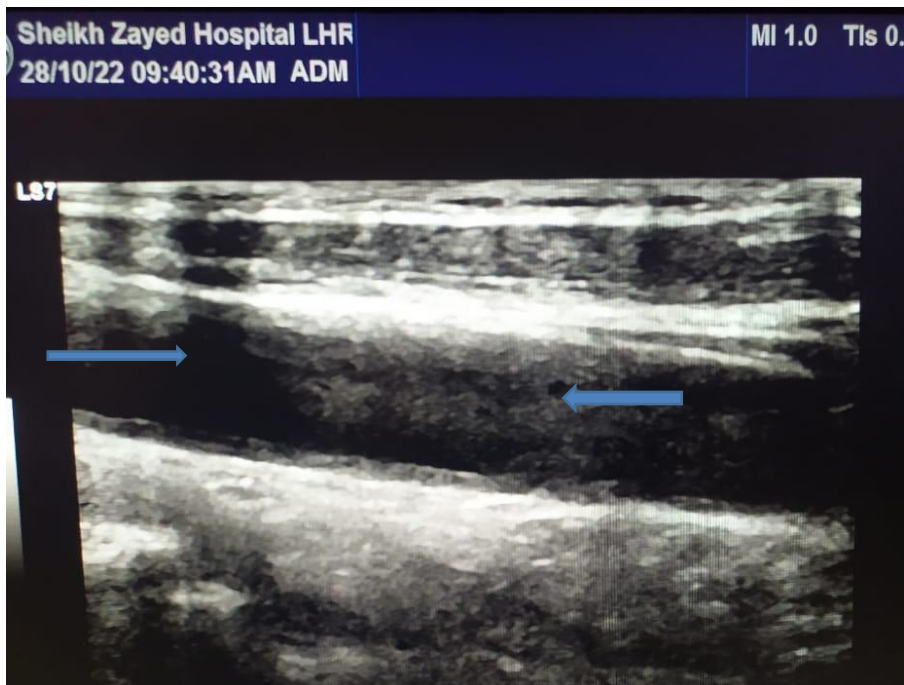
Sonographic image of axial view shows homogenous plaques in the carotid bulb of a right carotid artery causing stenosis < 70%. (Highlighted by blue arrows)
